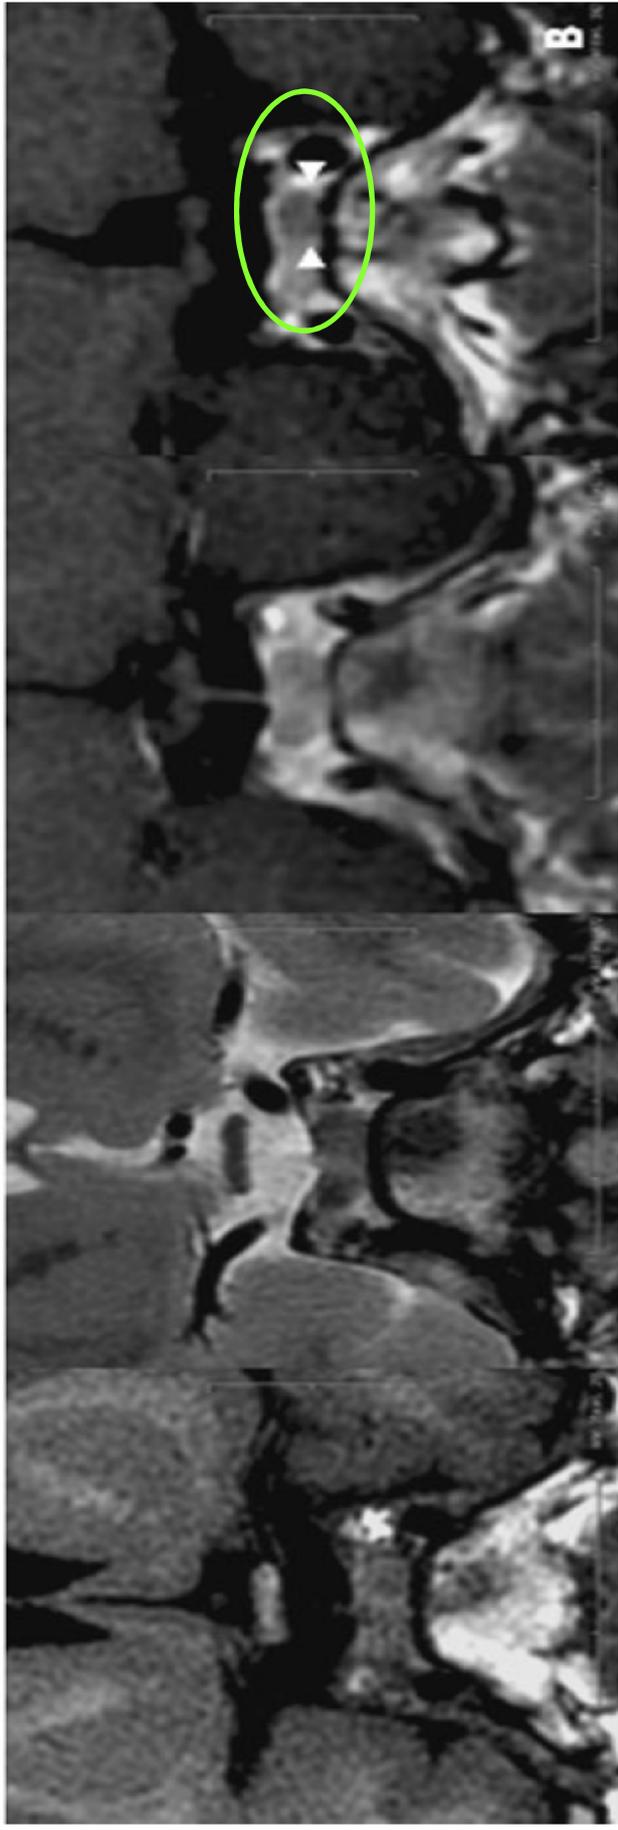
Two example cases showing the dynamic scans from a 1.5T MRI, and 3T without and with o-CRH stimulation. Both of these cases show the lesion more clearly on the 3T images (arrows), although there is not a clear difference between the o-CRH stimulated and nonstimulated images. Subject B paradoxically had angulation of the pituitary stalk towards the adenoma, likely as a result of the uneven sellar floor.
